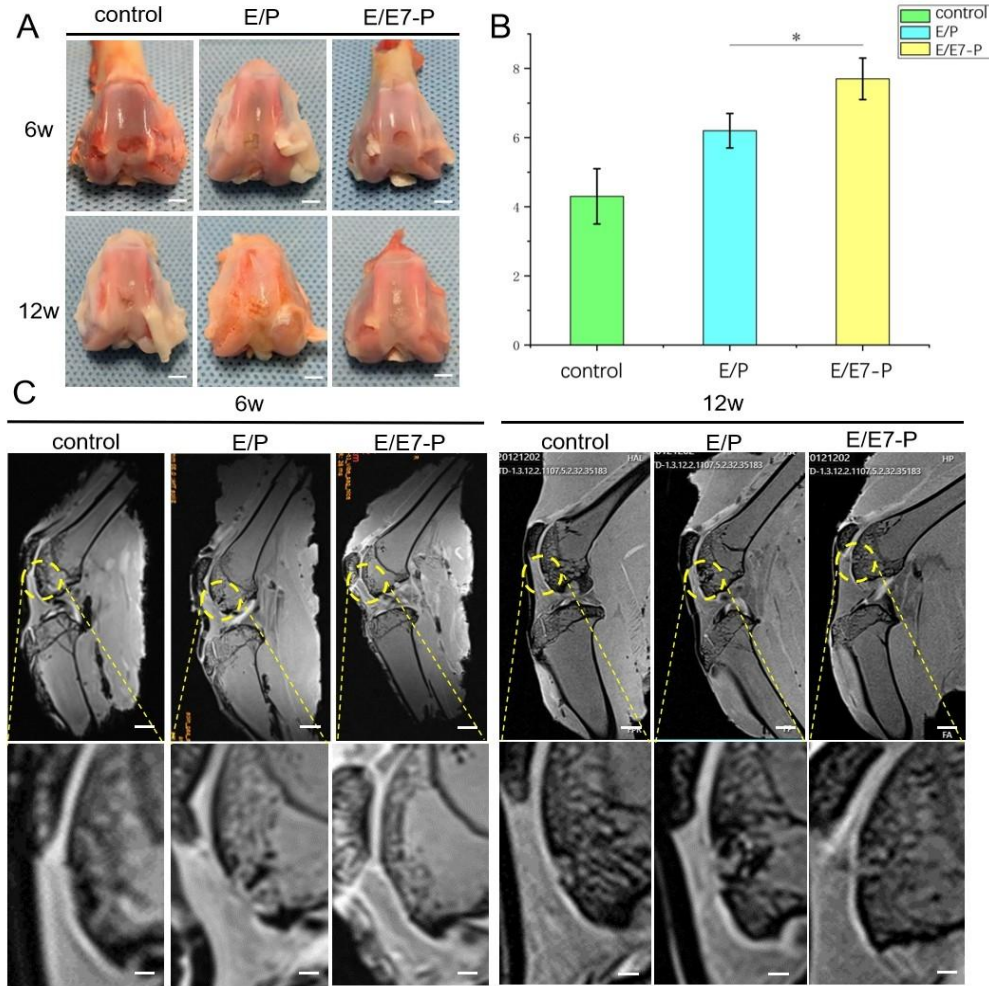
Gross observation, ICRS scoring and MRI evaluation of cartilage repair at 6 and 12 weeks postoperatively
